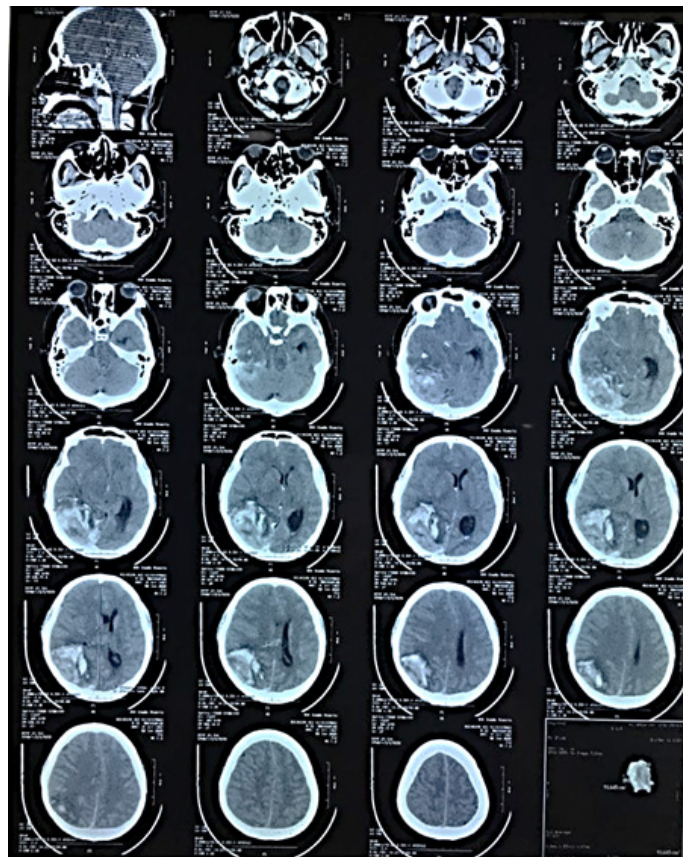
Head CT Scan Showed An Intracranial Hemorrhage in Right Parietooccipital Region with Midline Shift
